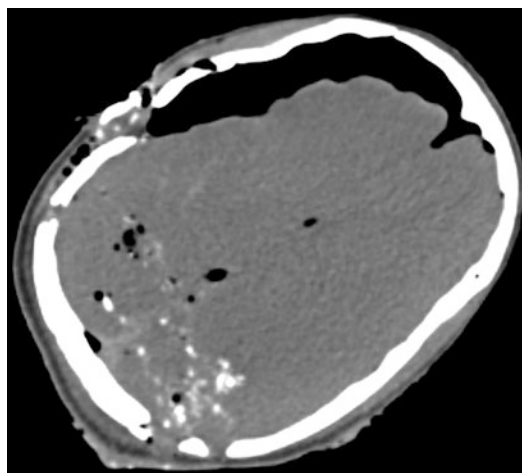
Axial noncontrast computed tomography (CT) scan showing pneumocephalus and multiple temporal and parietal fractures with minute osseous fragments along the trajectory of the bullet
